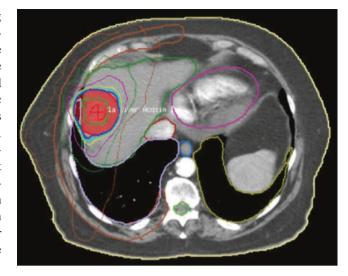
Computed tomography image demonstrating the planning field for stereotactic body radiation therapy (SBRT) in a patient with hepatic metastases unfit to tolerate surgical resection
